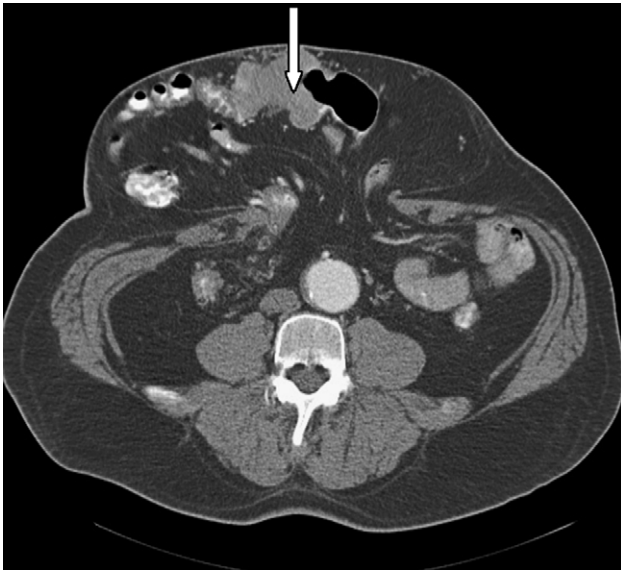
Computed tomographic scan of the abdomen revealing a 4 × 3 cm mass (*white arrow*) in the transverse colon within a large ventral hernia. Right and left are reversed by radiological convention.
